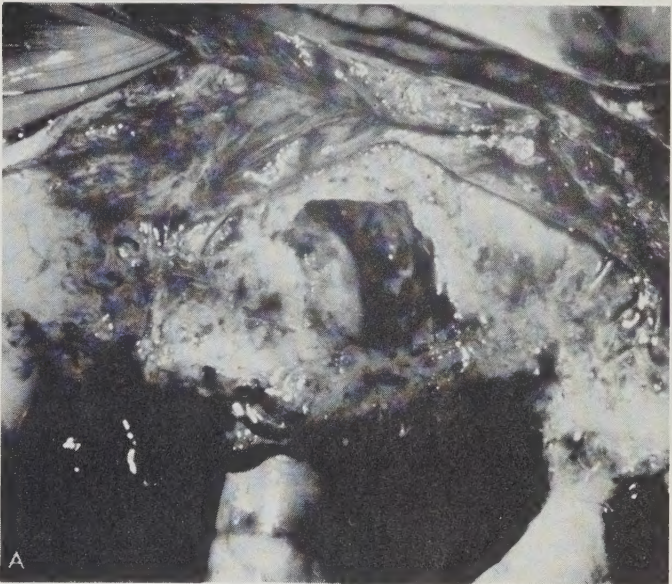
A. Fenestra in buccal surface of alveolar process and floor of maxillary sinus from periapical pathosis. B. Left, Roentgenograph made by "bisect-the-angle" technique does not show evidence of periapical pathosis. Right, The parallel technique and high Kvp. record distinct image of periapical roentgenolucency, but it appears smaller than the actual lesion.†
